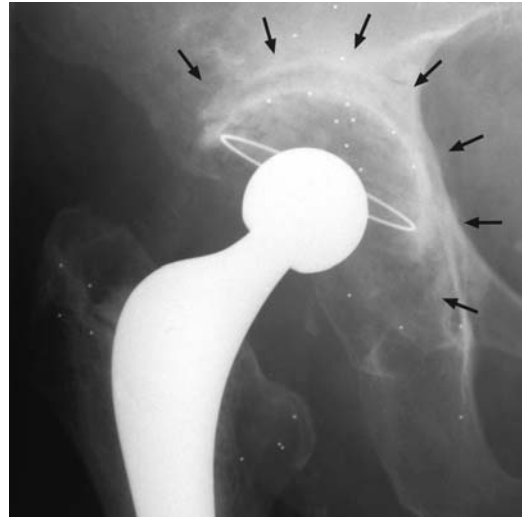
Socket 5 years after revision with impacted morselized allograft bone and cement with a radiolucent line  $>2\text{mm}$  in all 3 zones according to DeLee and Charnley (1976). Radiography also revealed allograft resorption and RSA major socket migration and rotation, but as the patient had no pain in the hip and the bone stock was not threatened rerevision was not considered.
